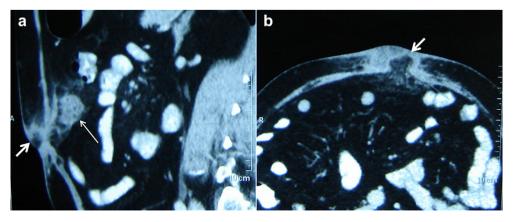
Computed tomography of the abdomen with sagittal (a) and axial (b) sections showing a small incisional hernia (thick white arrow) and an intrabdominal omental mass (thin white arrow) adjacent to hernia.
